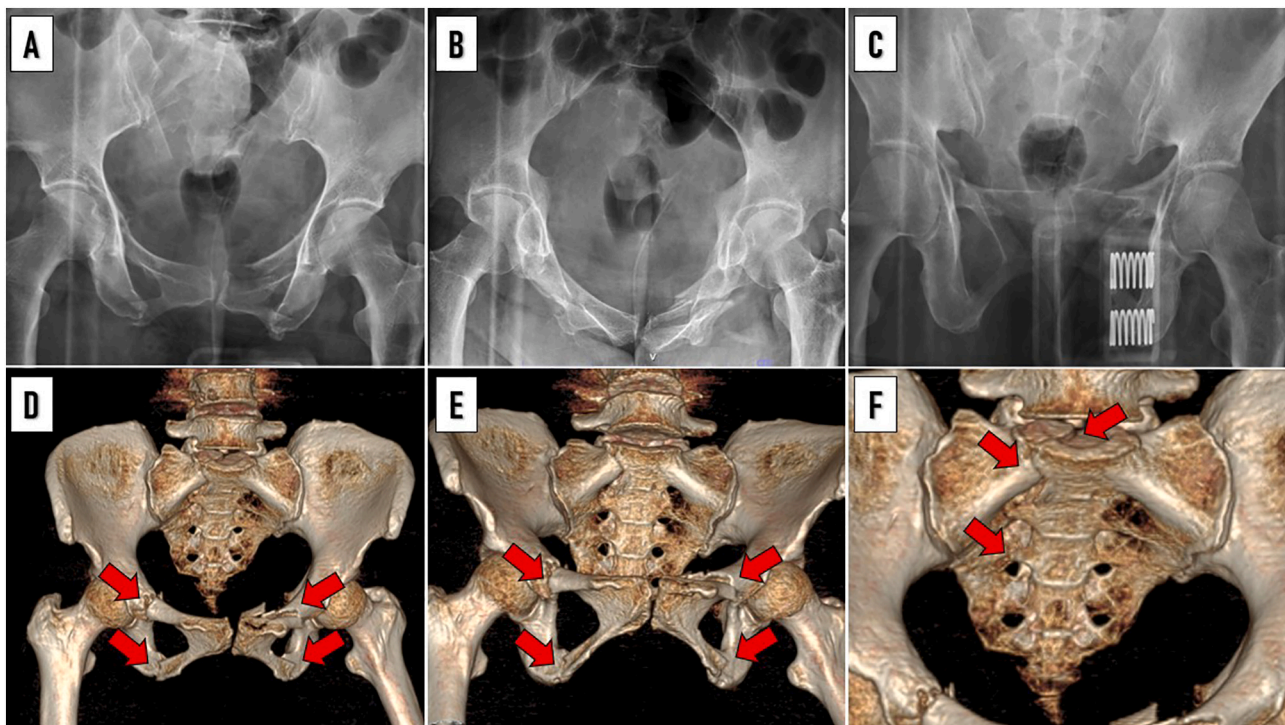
The initial radiographic study of the pelvis. Antero-posterior view (A), Inlet view (B), Outlet view (C). CT 3-dimensional reconstruction images showing straddle fracture and vertical sacral fracture (Denis classification type II) (D-E); Vertical sacral fracture (F).
